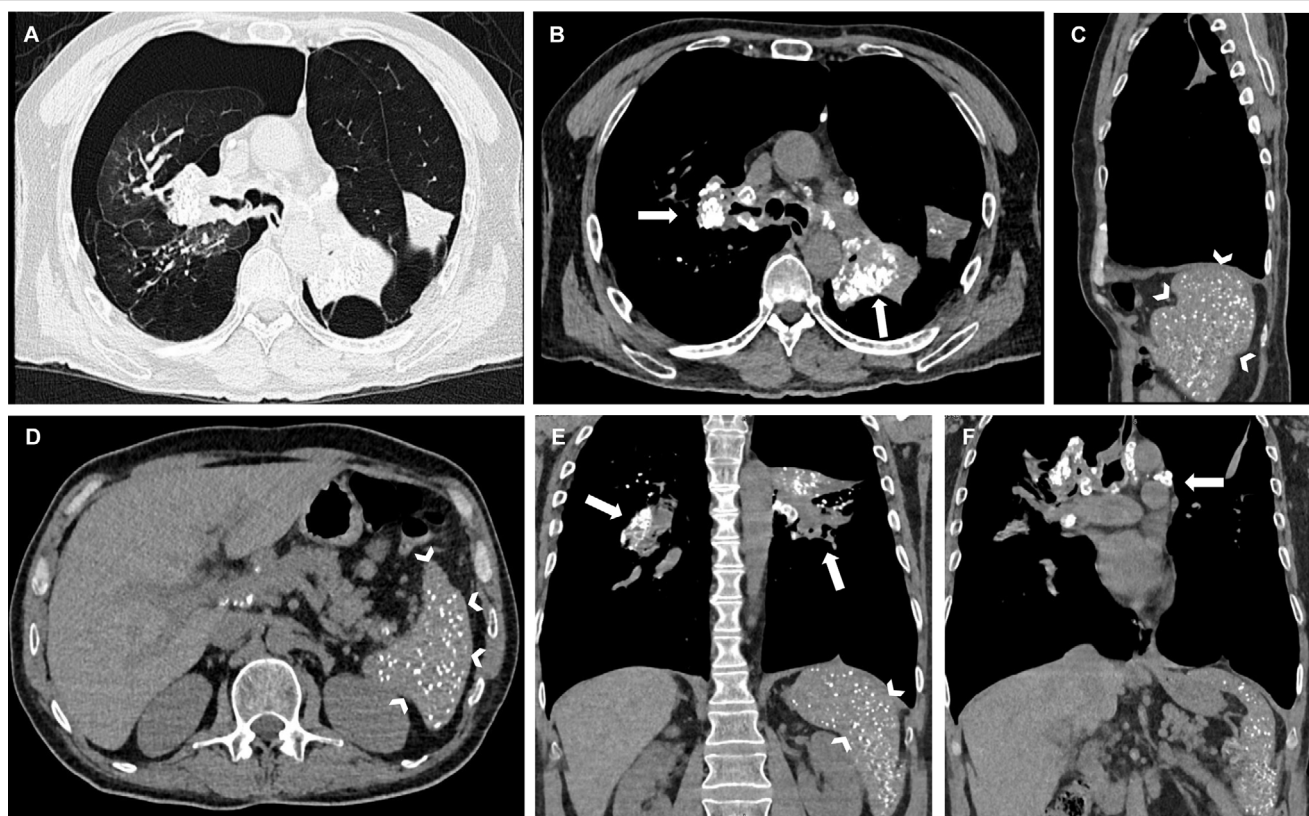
Chest CT scans in coronal and axial views. (Panel A) Right pneumothorax observed. (Panels B and E, arrows) show the presence of bilateral irregular calcified masses located in the hilar regions. (Panels B and F, arrows) Multiple “eggshell” calcifications of mediastinal lymph nodes. (Panels C–E arrowheads) Diffuse microcalcifications in the spleen.
